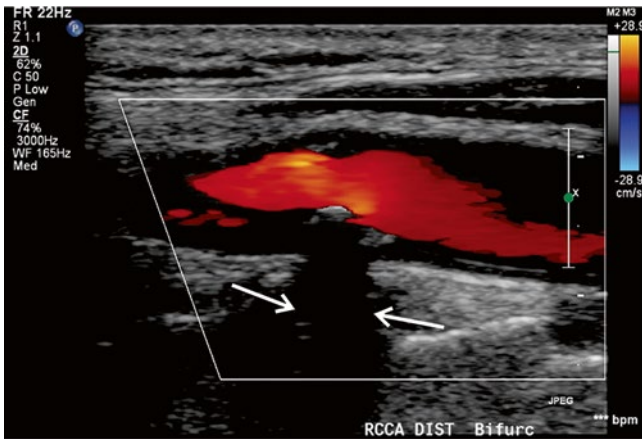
Color duplex ultrasound image of an internal carotid artery showing calcified plaque where a very dense acoustic signal is registered with acoustic shadowing (*arrows*)
